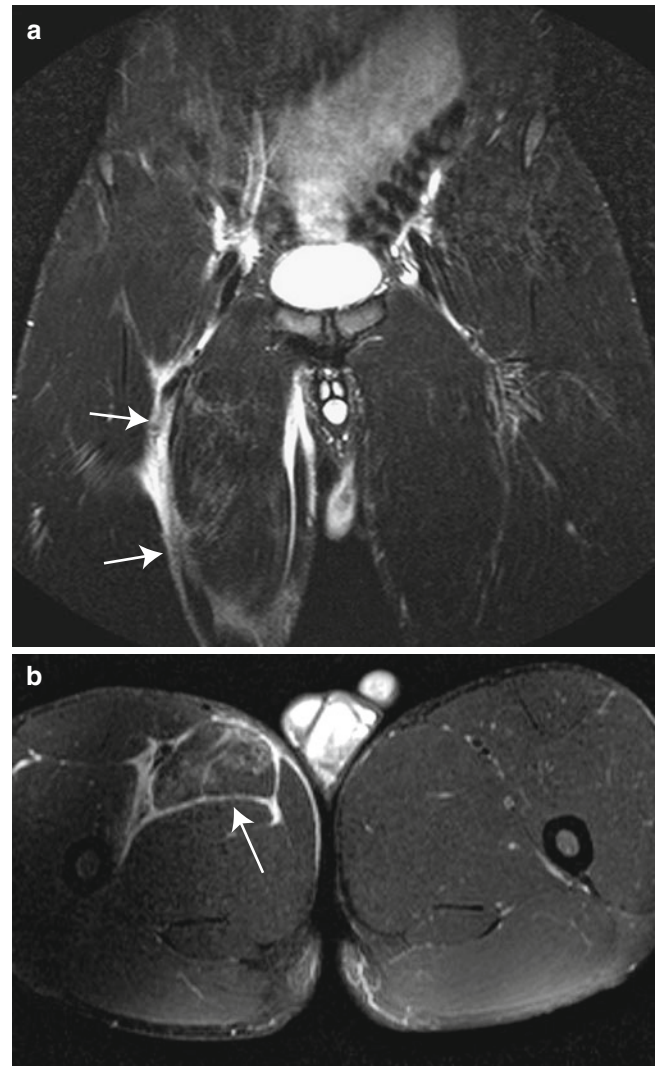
Coronal (a) and axial (b) MR images show extensive feathery edema throughout the right adductor compartment with enlargement of the pectineus and adductor longus and perimuscular edema (*arrows*) characteristic of baseball pitcher/hockey goalie syndrome
